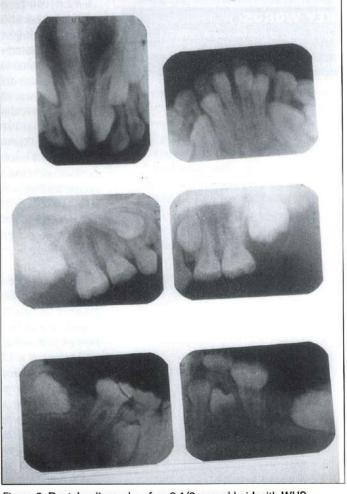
Dental radiographs of an 8 1/2 year-old girl with WHS.
